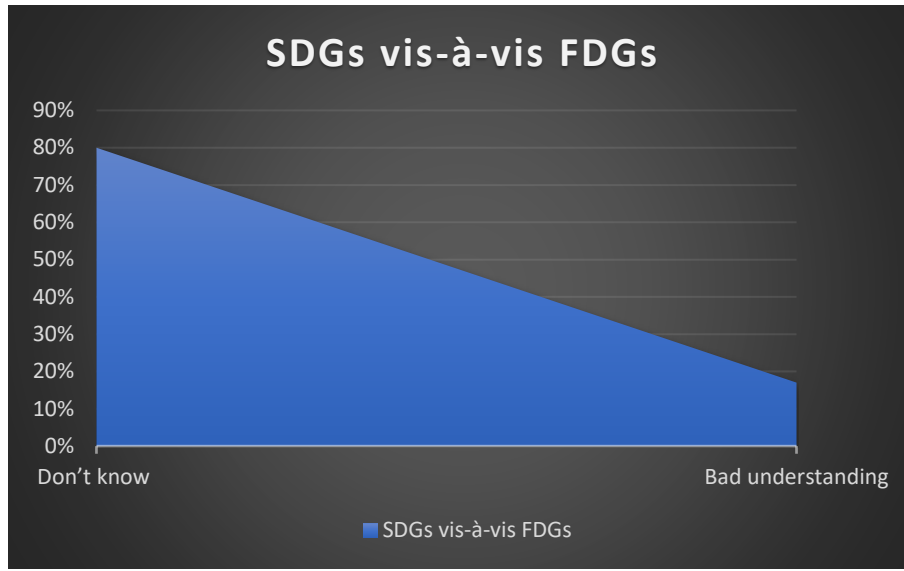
SDGs vis-à-vis FDGs
